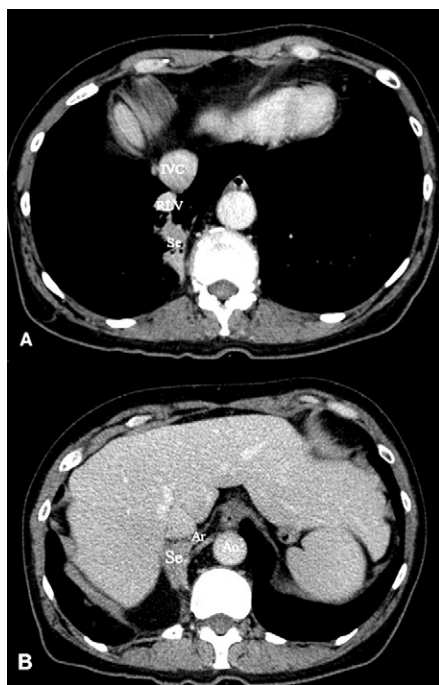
(A) Chest computed tomography scan showed intrapulmonary sequestration (Se) of the right lower lobe. The right lower vein (RLV) is anterior to the sequestration with drainage directly in the inferior vena cava. (B) Vascularisation of the sequestration by an aberrant artery (Ar) arising from the sub-diaphragmatic descending aorta (Ao).
